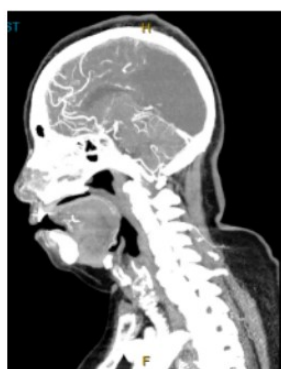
CT Head and Neck angiogram Sagittal view. Shows left posterior lobe infarct and PCA occlusion Left side. Corresponds to dashed line in figure 1
